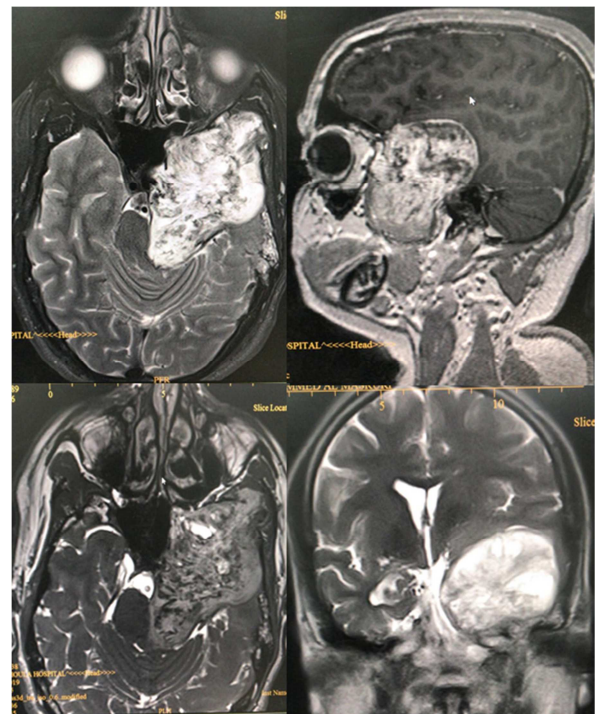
MRI images of the brain and base of skull with different modalities showing a large enhancing cystic hemorrhagic mass along the course of the left trigeminal nerve. The lesion is causing significant mass effect on the adjacent structures including cavernous sinus structures (left cavernous ICA), brain parenchyma with compression of the left lateral ventricle. Inferiorly, the lesion extends into the left masticator space likely through the left foramen ovale. There is a mass effect on the left side of the nasopharynx causing obstruction of the Eustachian tube opening and left mastoid effusion. There is also compression of the brainstem.
